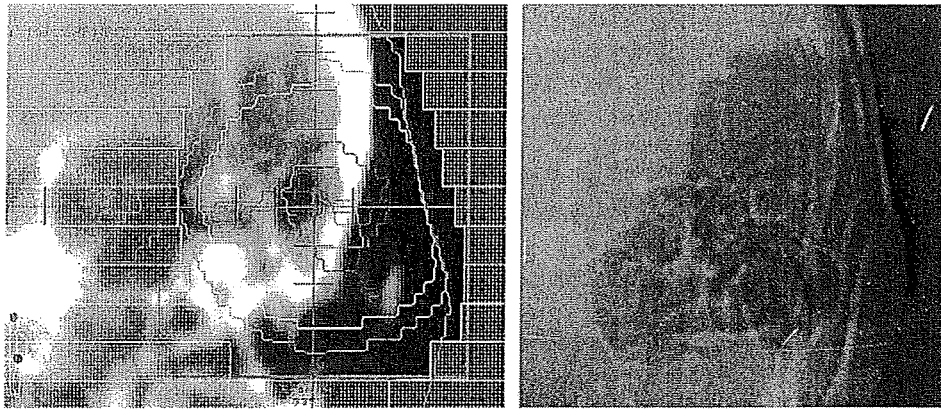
Digitally reconstructed radiograph showing irradiation field (left) and portal film (right) for patient with orbital mucosa-associated lymphoid tissue (MALT) lymphoma.
